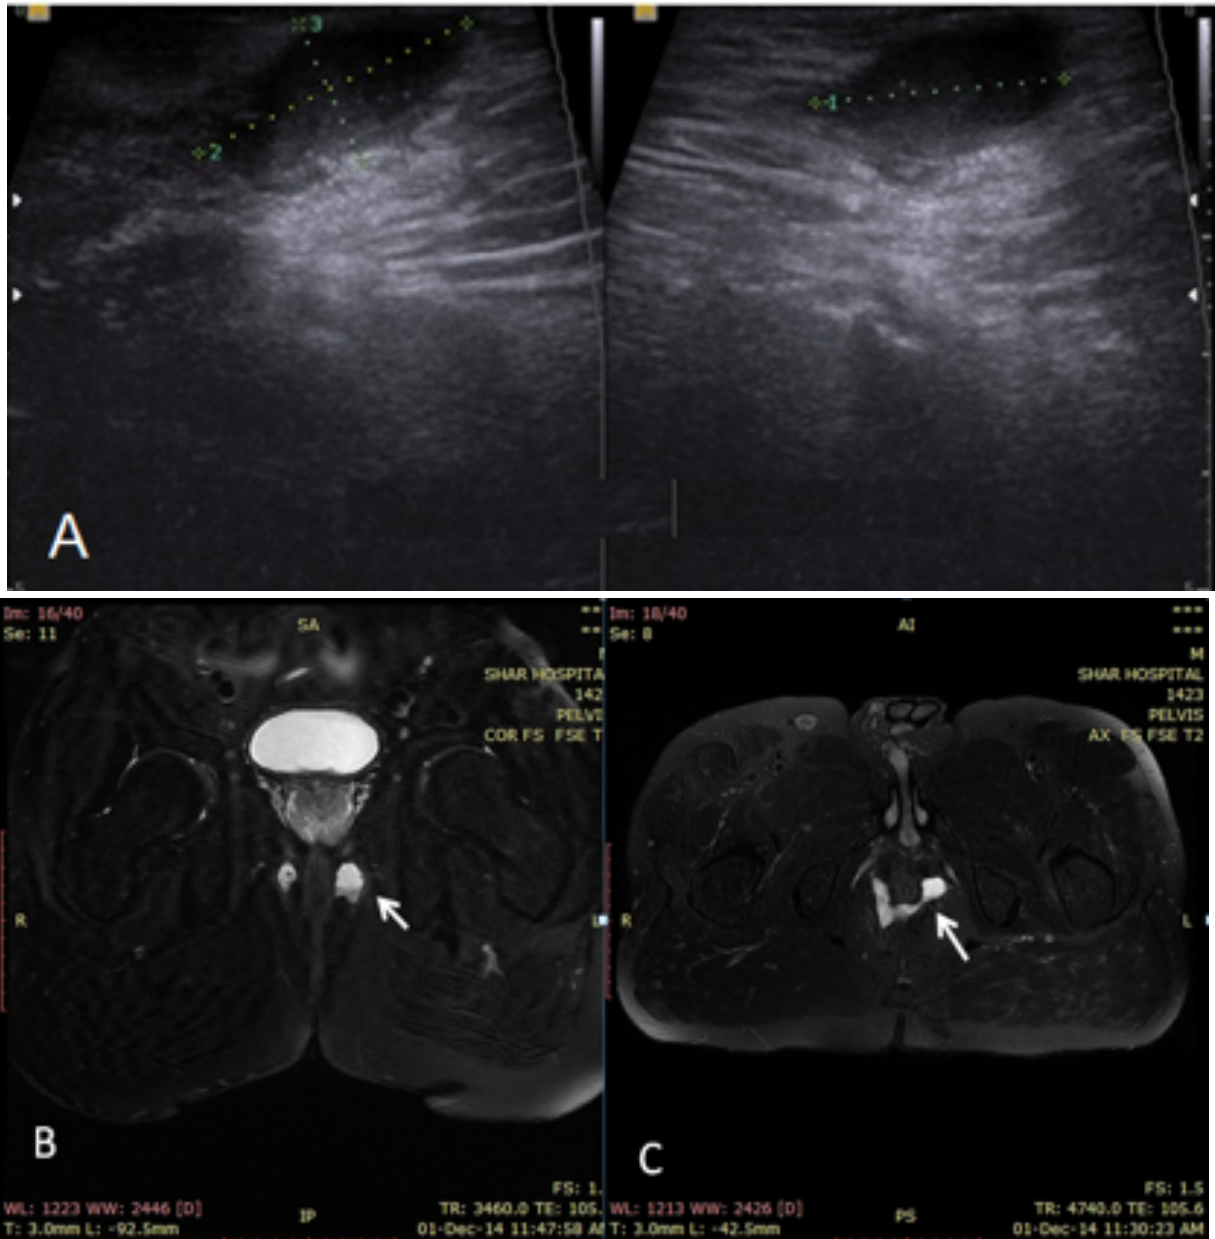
Perianal abscess collection. A. TPUS, B and C. T2WI fat suppression MRI in coronal and axial sections, showing an abscess (A and B) as well as branching and U shaped extension (C) in the intersphincteric plane (arrows).
